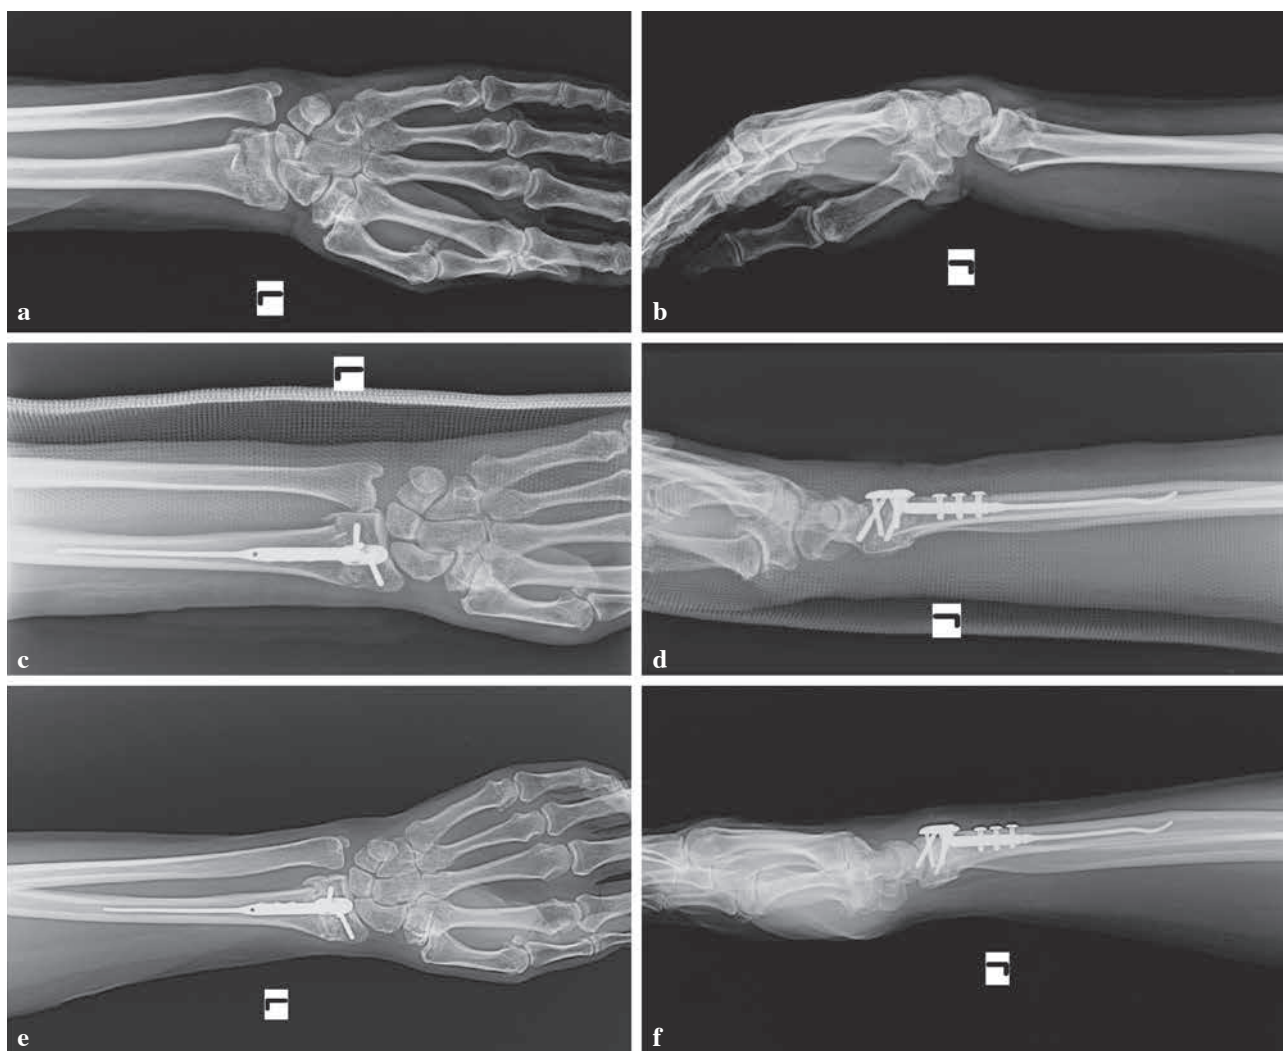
DNP surgical method a) preoperative anterior-posterior x-ray b) preoperative lateral x-ray, c) early postoperative anterior-posterior x-ray, d) early postoperative lateral x-ray, e) 12 week follow up postoperative anterior-posterior x-ray, f) 12 week follow up postoperative lateral x-ray.
